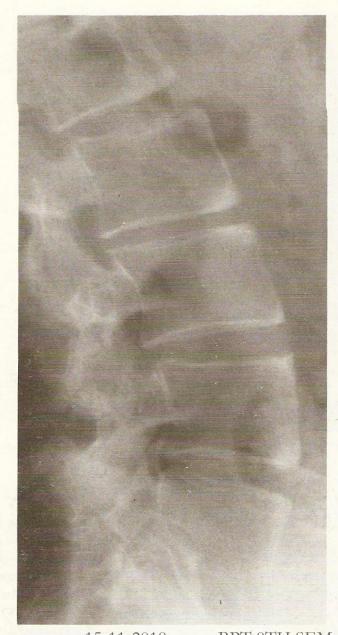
Lateral radiograph of lumbar spine showing vertebral squaring with sclerosis at the attachment of the anterior portion of the annulus fibrosus.
